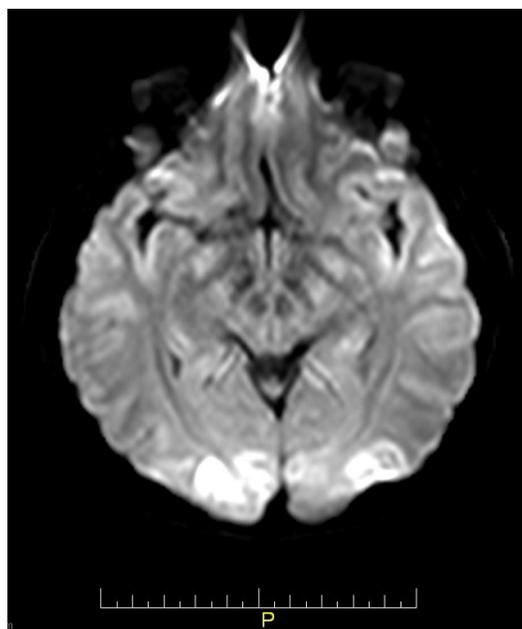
Magnetic resonance imaging diffusion-weighted image (DWI) revealing restricted diffusion predominantly over the right occipital lobe, suggesting edema and recent ischemia.
